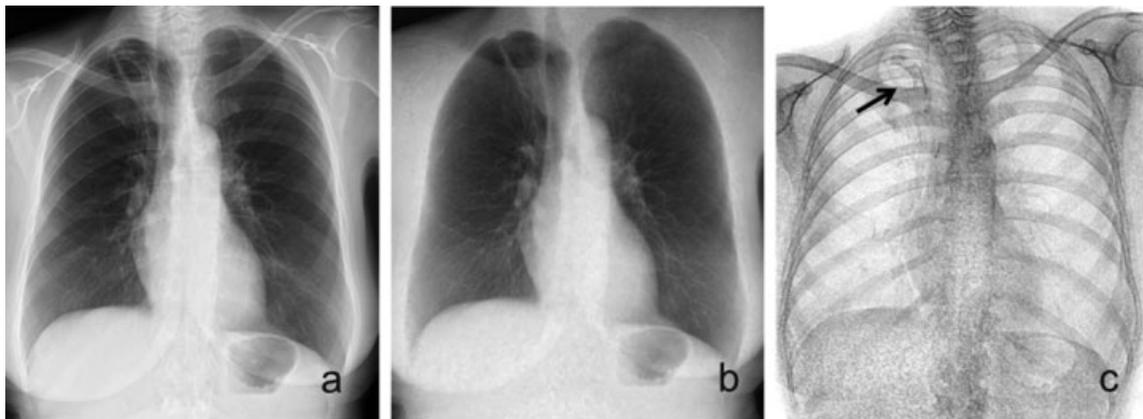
PA radiograph (a) with circular opacification in the right upper lobe suspicious for a cavitation. Soft tissue (b) and bone image (c) produced by dual energy subtraction technique demonstrate a linear scarring (b) and a radio-opaque vascular stent (c, arrow) as explanation for the circular opacity. Image courtesy of Peter Vock, Chief of Diagnostic, Interventional, and Pediatric Radiology, University Hospital of Bern, Bern, Switzerland. PA, posterioranterior.
